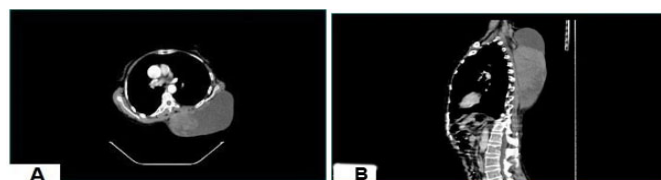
Computed tomography images. (A) The axial CT plane shows a large mass on the left side. (B) The sagittal CT plane shows the mass on the back, which occupied most of the left region.
